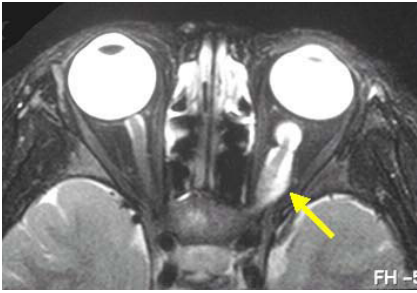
Axial magnetic resonance imaging of case 1 revealed a mass measuring 2.3×0.5 cm (arrow). It enclosed and adhered to the optic nerve.
